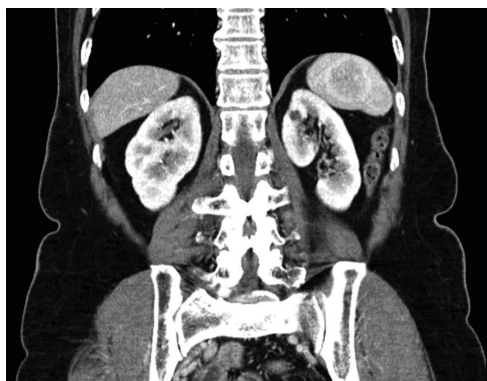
Abdominal computed tomography scan revealing a homogeneous round splenic mass with rim enhancement.
